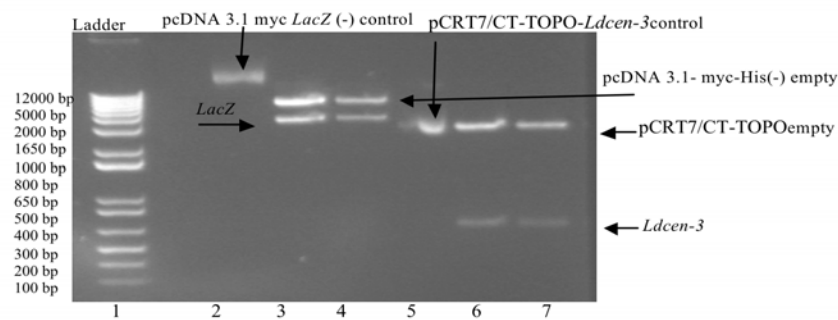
Digestion of pcDNA 3.1 and pCRT7/CT-TOPO: Both plasmids were cut by XbaI and Hind III restriction enzymes: 1- ladder; 2- pcDNA 3.1 myclacZ (-); 3, 4-the above band is the linear - empty pcDNA 3.1 myc-His and lower band is lacZ; 5, pCRT7/CT-TOPO-Ldcen-3 control; 6, 7, above band is the linear empty vector pCRT7/CT-TOPO and lower band is Ldcen-3.
